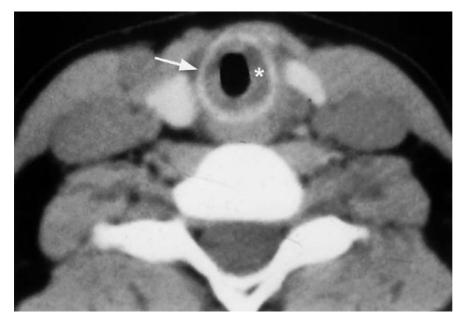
Wegener's granulomatosis subglottic larynx. Axial computed tomography section shows diffuse soft tissue thickening of the subglottic larynx (asterisk) adjacent to the cricoid cartilage (arrow).
